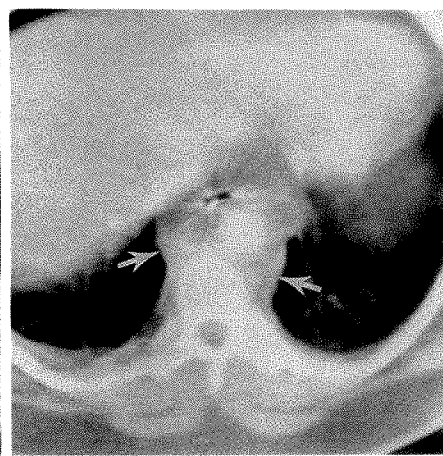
CT shows mediastinal hemorrhage and aortic contour irregularity. Chest radiographs obtained on admission in this obese 48-year-old man after a motor vehicle accident were equivocal because of body habitus and underexposure. A chest radiograph could not be obtained with patient erect because of concurrent orthopedic injuries.
